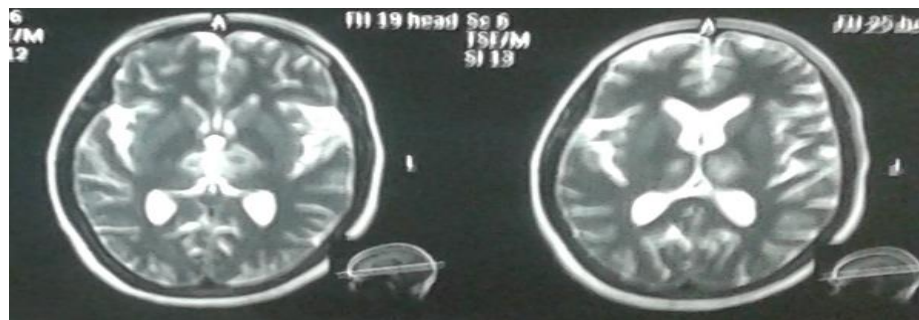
T2 weighted image of MRI Brain showing hyper intensity involving bilateral thalami
